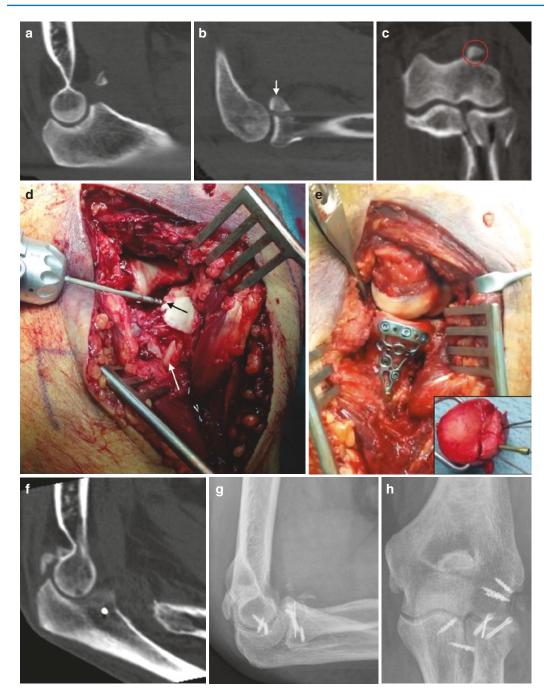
Operative treatment of a terrible triad injury with ORIF of the radial head and suture anchor refixation of the coronoid tip. (\mathbf{a} - \mathbf{c}) Preoperative CT scans revealing a displaced coronoid fracture (O'Driscoll type I.2) (\mathbf{a}) and a multi-fragmentary radial head fracture (\mathbf{b} , \mathbf{c}). The red circle (\mathbf{c}) depicts a radial head fragment which lies at the posterior aspect of the capitulum as a result of the dislocation. (\mathbf{d} , \mathbf{e}) Intraoperative photographs. Lateral view through a Kocher approach. (\mathbf{d}) After resection of the coronoid tip (black arrow) is performed. The white arrow
